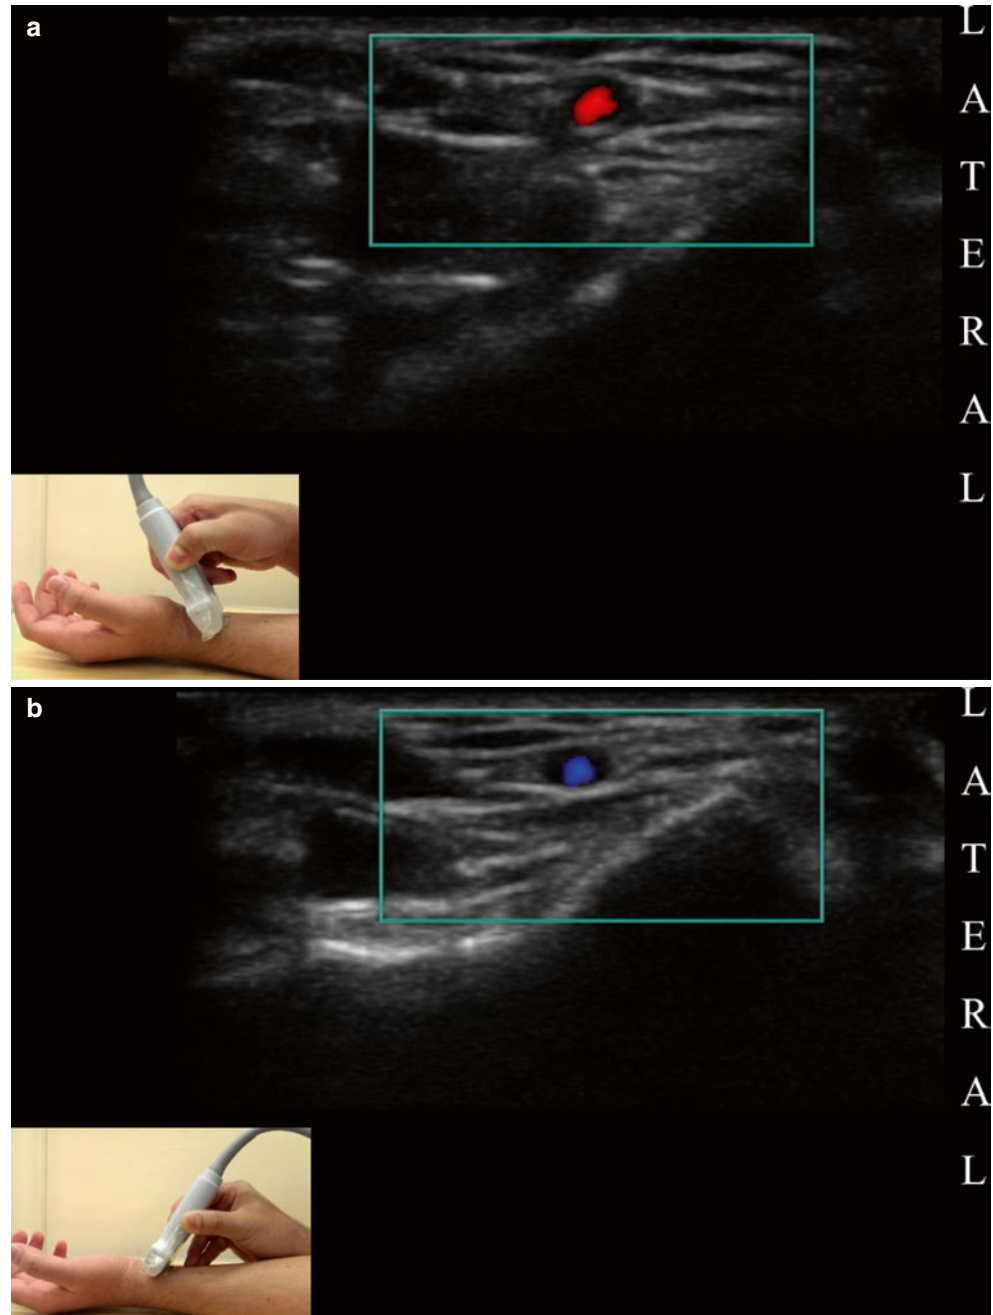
Use of color-flow Doppler for detection of blood flow in radial artery: (a) *red*, toward the transducer; (b) *blue*, away from the transducer (Reproduced with permission from www.regionalfortrainees.com)
